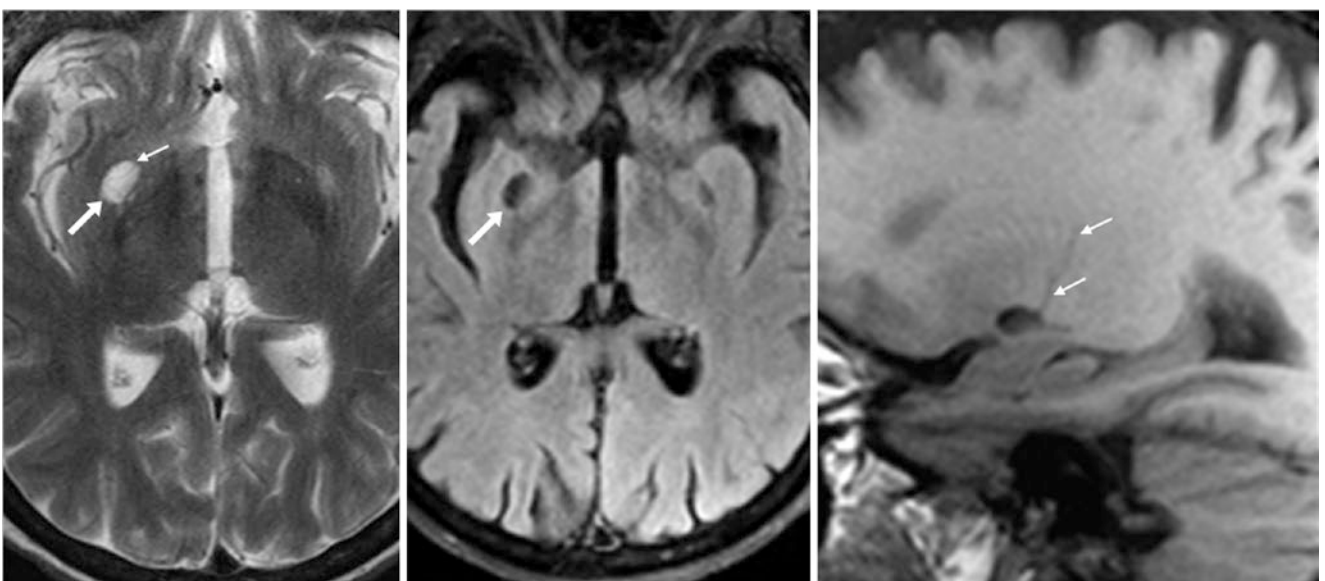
A 55 year old with a dilated PVS (arrows) within the anterior perforated substance/inferior putamen on a 3T axial T2WI MRI (left) in which a faint, tiny, perforating lenticulostriate vessel may be seen (tiny arrows, left). The PVS suppresses on FLAIR (middle). A sagittal T1WI MRI of the right side (right) also depicts the perforating vessel as it penetrates and passes through the dilated PVS. Note a smaller, dilated PVS on the left side in a similar location
